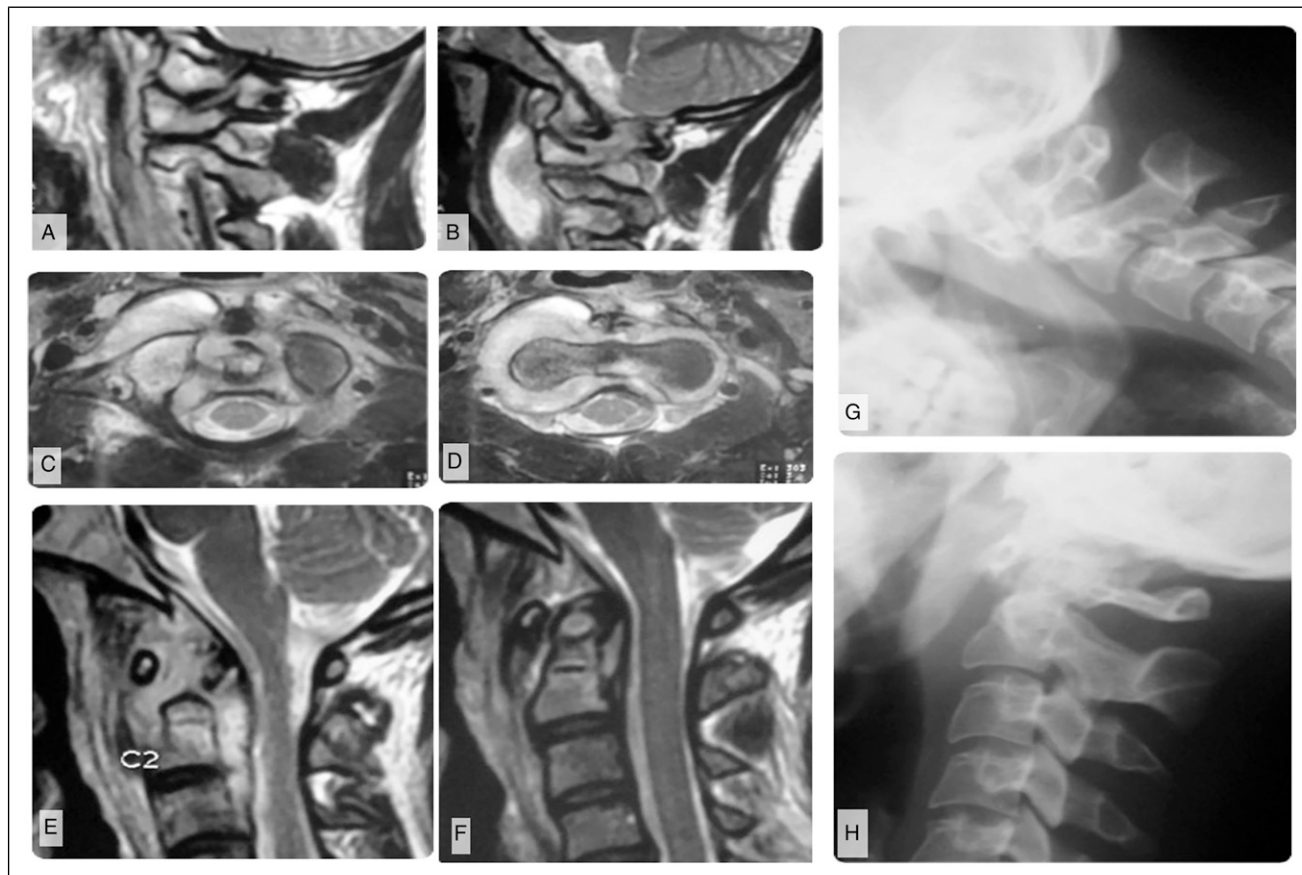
Imaging of a patient with modified Lifeso Stage I disease. (A) Parasagittal MRI shows abscess formation around the lateral atlantoaxial joints and (B) elevation of the prevertebral musculature. (C–D) Demonstrates that the abscess does not violate the prevertebral fascia, but may track into the epidural space through the neural foramina. (E) Parasagittal T2-weighted MRI shows that the abscess preferentially involves sites with an articular surface but (F) sagittal images show no ligamentous incompetence or bony destruction. This is similarly reflected on (G) flexion and (H) extension plain films.
